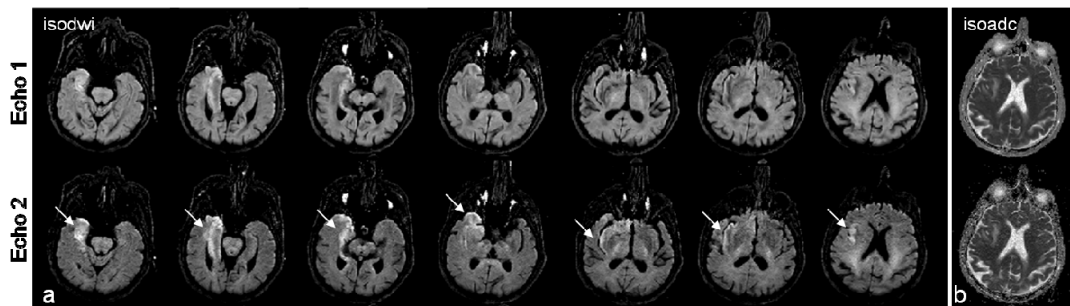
Patient data acquired on an 88yr old male stroke patient. (a) Coil sensitivity-corrected isotropic DWI ($b=1000\text{s/mm}^2$) dual echo images showing increased lesion conspicuity on the second echo (white arrows). (b) Single slice from the same dataset showing the isotropic ADC calculated from the $b=0$ and DWI images from echo 1 (top) and echo 2 (bottom), respectively. The isoDWI echo 2 may be useful for lesion conspicuity, while isoADC echo 1 could be used for its higher SNR.
